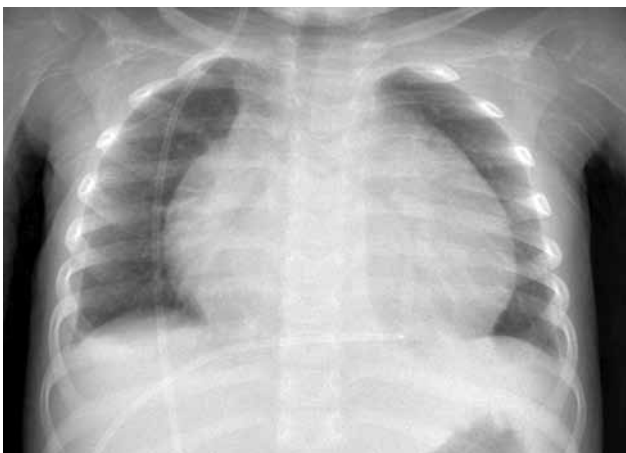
Chest X-ray showing the cardiomegaly and ventriculoperitoneal shunt catheter tip in the pericardium.
